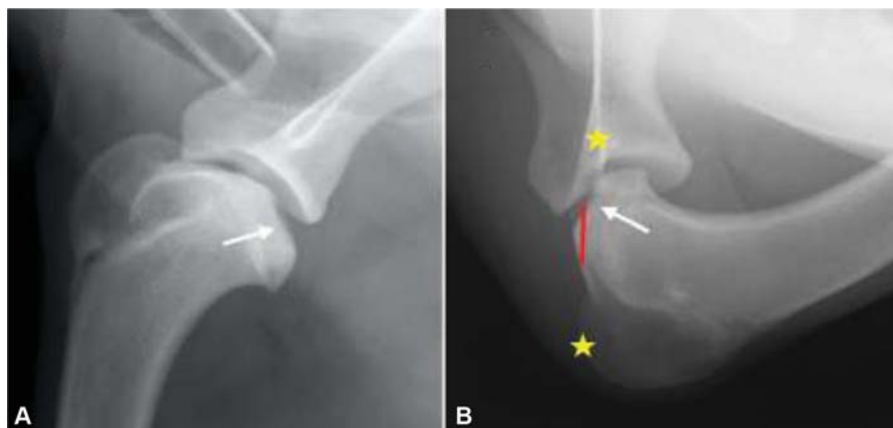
(A) Neutral radiographic view of the shoulder of an English Setter with osteochondritis dissecans (OCD) showing the lesion on the caudal surface of the humeral head (white arrows). (B) Forced hyperflexion of the shoulder joint, as proposed by Cheli in 1984, moves the caudal surface of the humeral head cranially. The yellow stars indicate the landmarks for the direction of the skin incision, approximately midway between the cranial edge of the acromion process and the proximal greater humeral tubercle. The red line indicates the joint approach for direct access to the OCD lesion.
